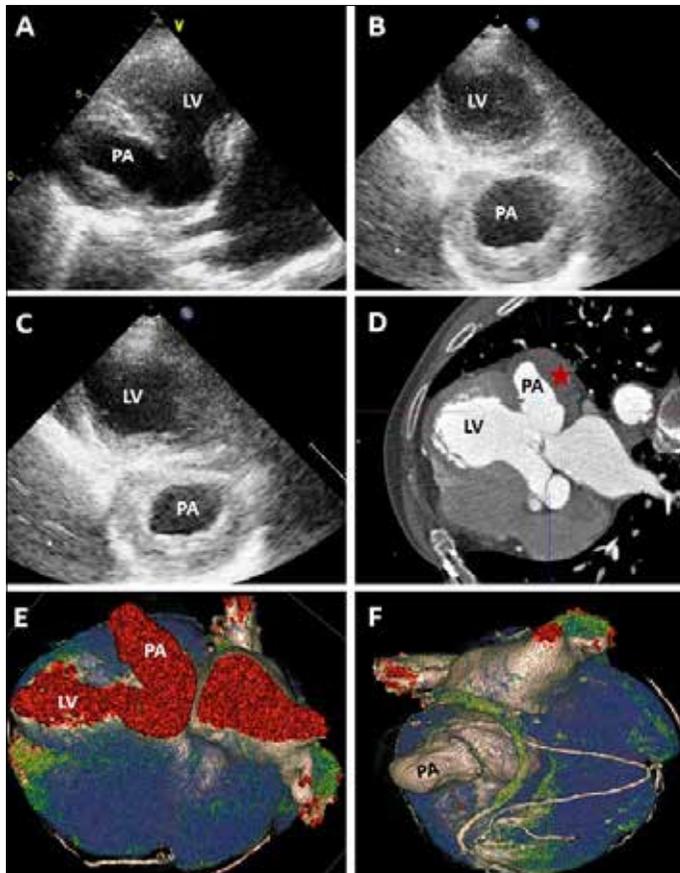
A) Apical long -axis view showing the shape of “lovely heart”. B-C) Parasternal short -axis view showing dyskinesia. D) CT Angiography showing thrombus formation in the pseudoaneurysm. E-F) 3D reconstruction of cardiac CT Angiography
